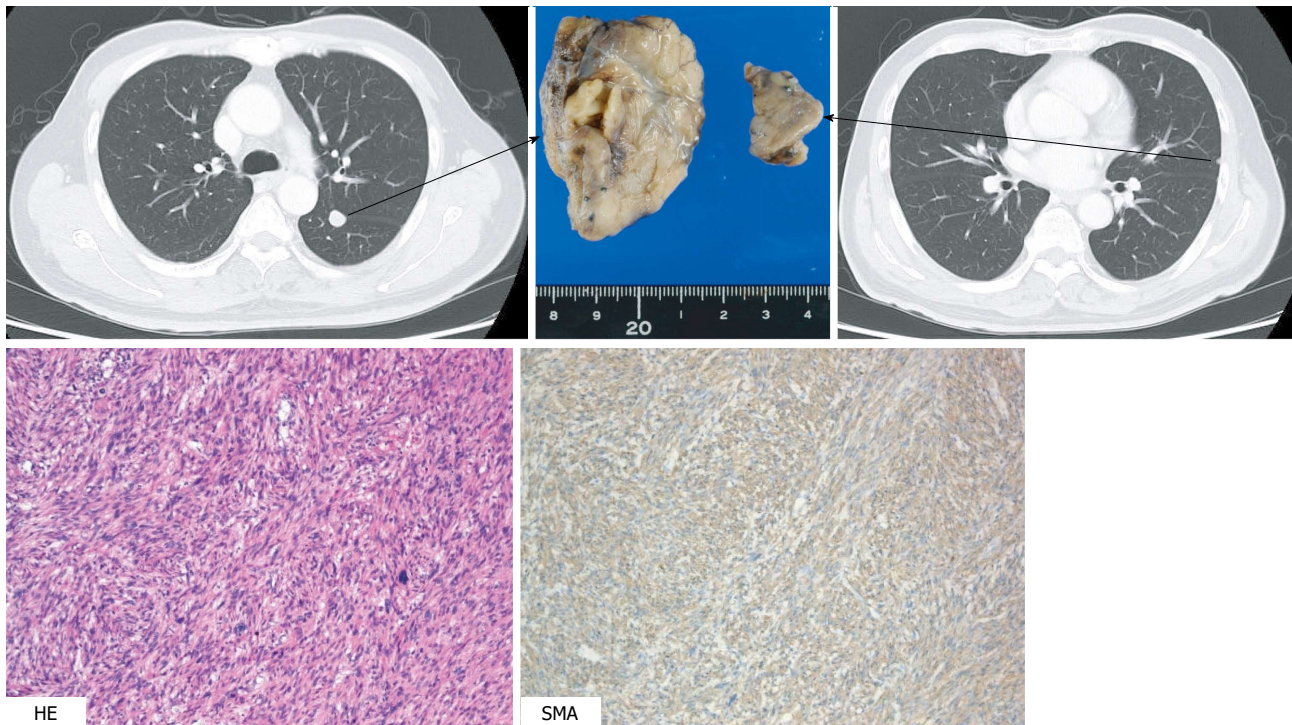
Lung recurrences. In a chest CT scan, two coin lesions were discovered in the left lung. As lung metastases were strongly suspected, partial resections of the left upper lobe and left lower lobe were performed. Pathological diagnosis was metastatic leiomyosarcoma of the lung.
